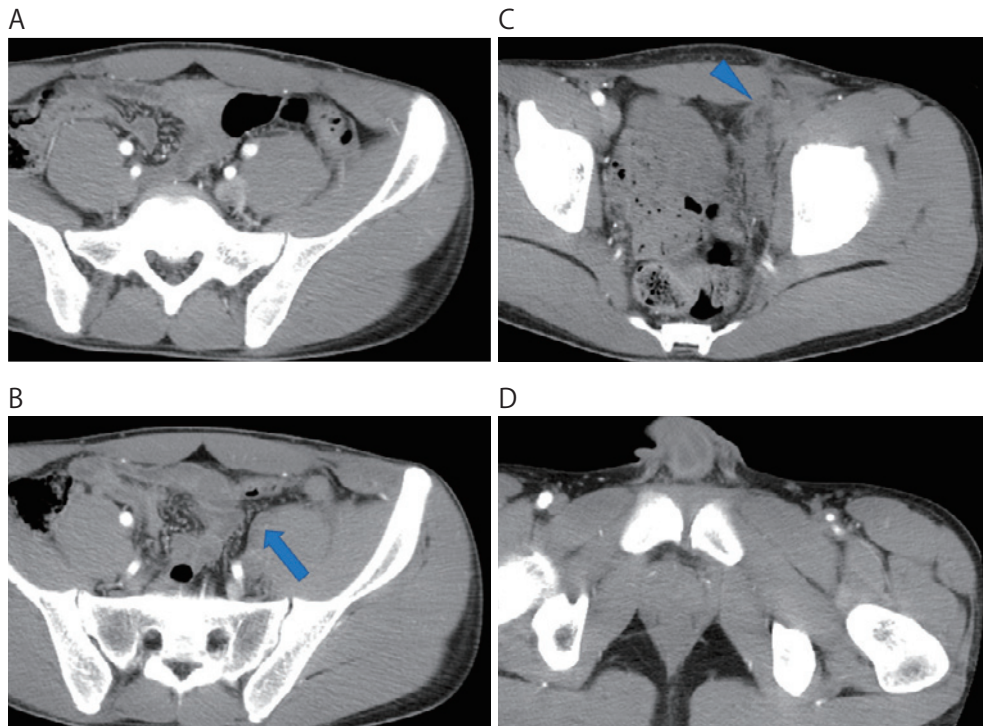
Sequential axial images of pelvic contrast-enhanced CT show a persistent left external iliac artery (A), thrombosed lumen (B), severe contusion at the site of the lesion (C), and patent left common femoral artery with perivascular edema (D).
